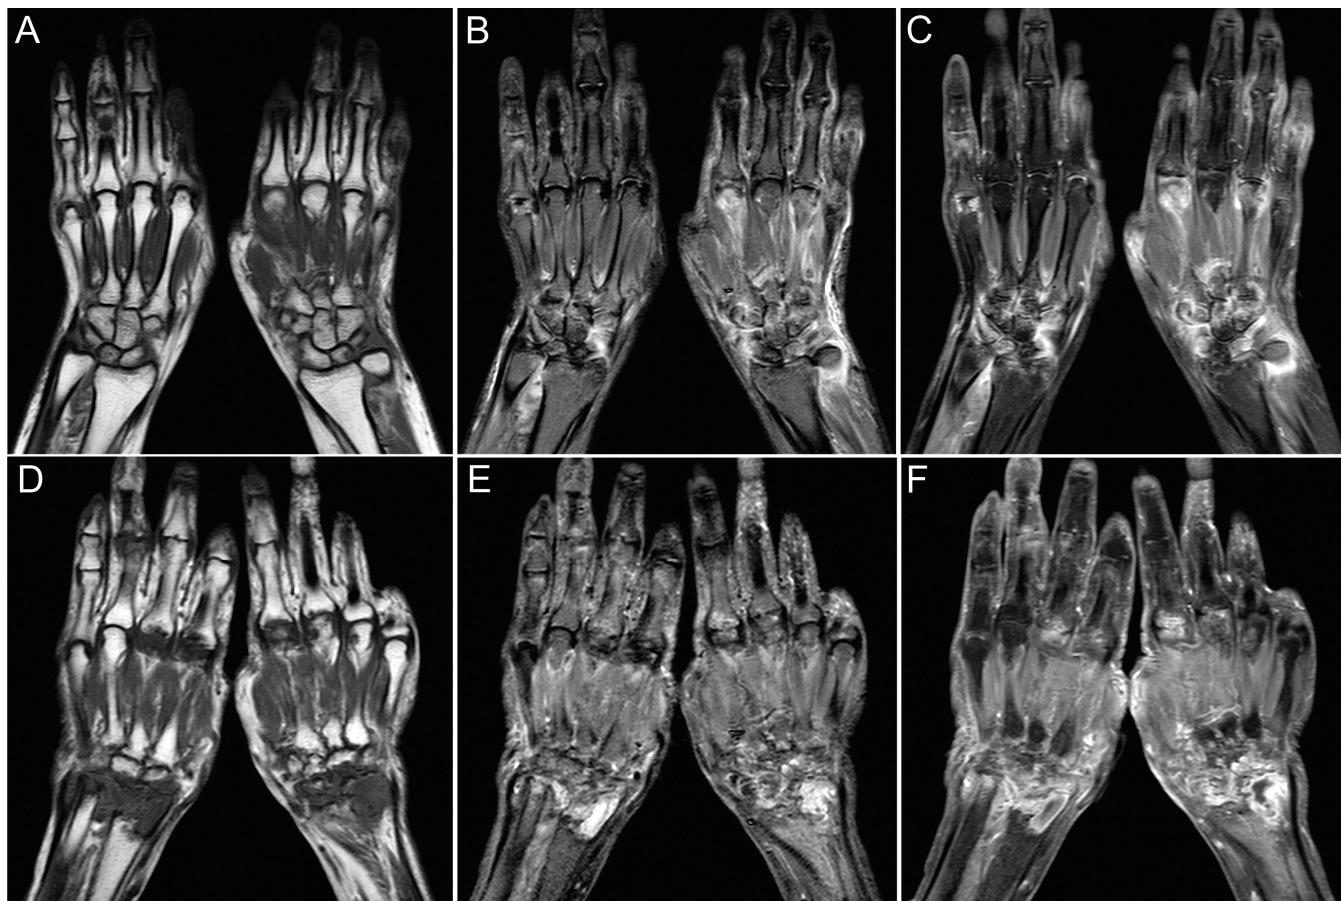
Typical MRI images of bilateral hands in 2 patients with RA. One was a 44-year-old woman and diagnosed with early RA (7 mos disease duration). Marked synovitis, osteitis, and bone erosion were shown in MRI (A–C). The other patient was a 64-year-old woman with 84 months of disease duration. Synovitis, osteitis, and bone erosion were shown as more severe in the nondominant hand versus the dominant hand (D–F). A and D. Coronal spin echo T1-weighted imaging. B and E. Coronal turbo spin echo fat-suppressed T2-weighted imaging. C and F. Contrast-enhanced coronal spin echo fat-suppressed T1-weighted imaging. MRI: magnetic resonance imaging; RA: rheumatoid arthritis.
